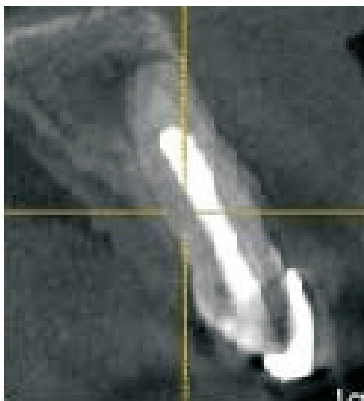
CBCT image of lateral incisor after one year
